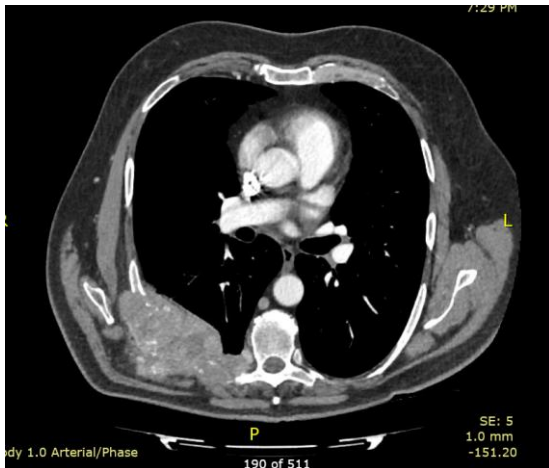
CT demonstrating right seventh rib with large vascular soft tissue component measuring 12 cm in diameter
